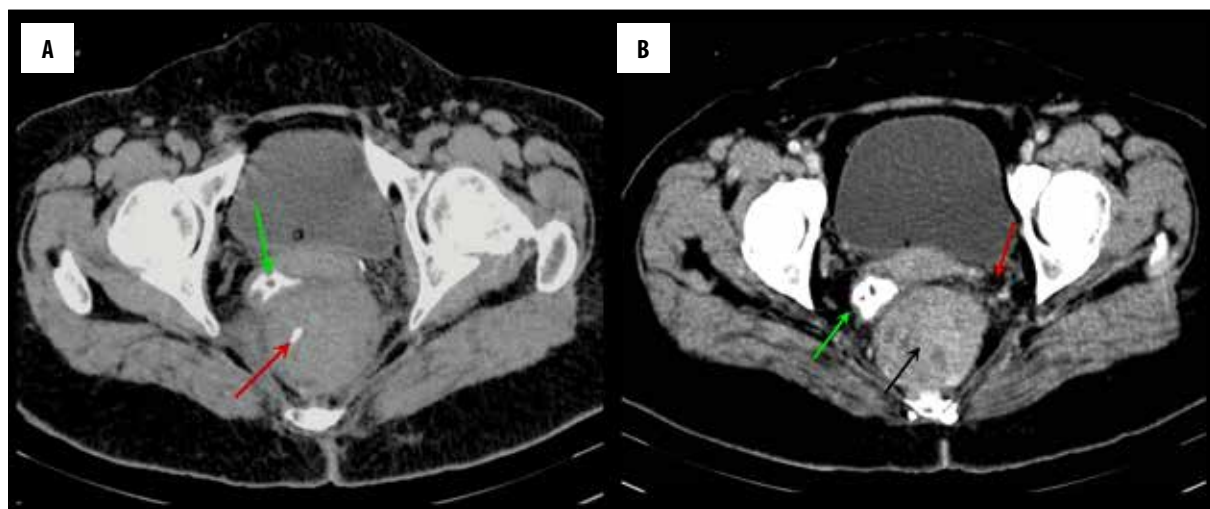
(A) Non-contrast-enhanced CT scan of the pelvis reveals a solid presacral tumour with foci of calcifications, (red arrow), which compresses and displaces the contrast-filled rectum (green arrow) to the right side. (B) Contrast-enhanced CT scan of the pelvis reveals a moderately enhancing presacral tumour with necrotic foci (black arrow) and peri-tumoral infiltration (red arrow). The rectum is compressed and displaced to the right side (green arrow).
